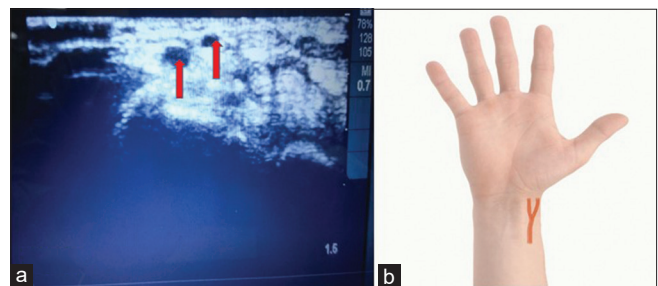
(a) Ultrasound image in short axis showing two pulsating arteries. (b) Pictorial representation of anatomical variation in radial artery
